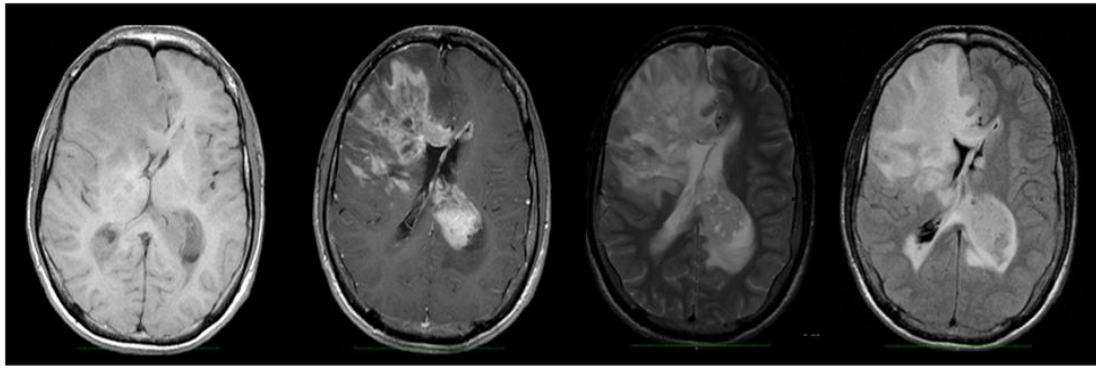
Different modalities taken with different MRI techniques. From left to right: T1, T1-enhanced, T2, T2 flair.
